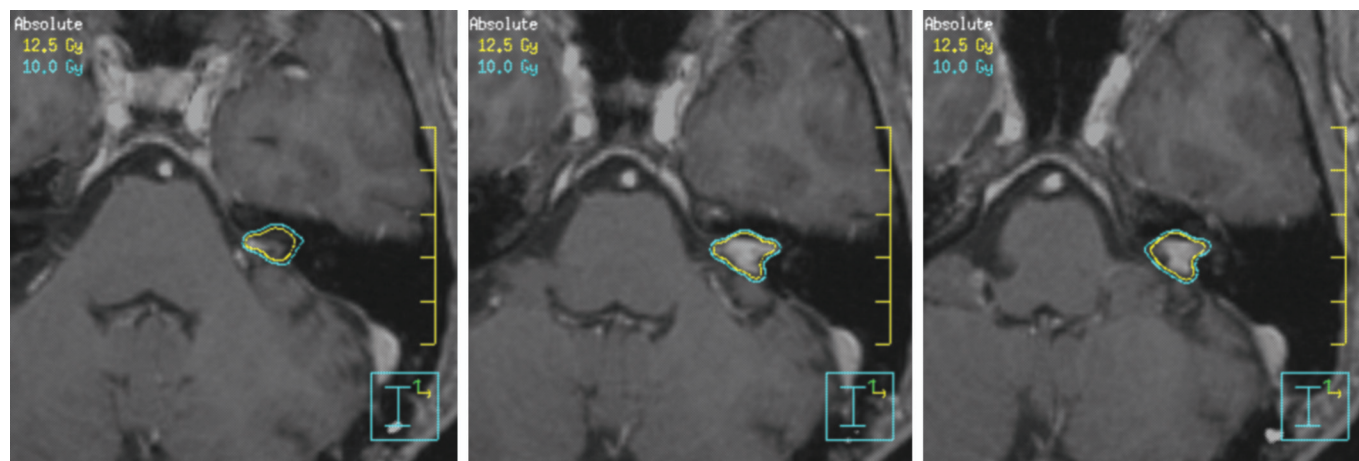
Three selected axial cuts through a vestibular schwannoma showing the resulting conformal treatment plan using four different isocenters. The gadolinium contrast enhanced thin slice T1-3D-SPGR MRI data set has been fused to the underlying stereotactic computed tomography (CT) to visualize the vestibular schwannoma. The 12.5-Gy treatment isodose line and the 10-Gy isodose line are shown.
